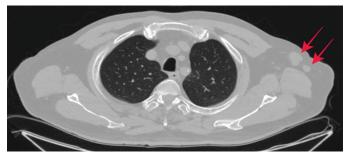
Transverse view of chest CT scan with IV contrast; enlarged axillary lymph nodes (arrows).
